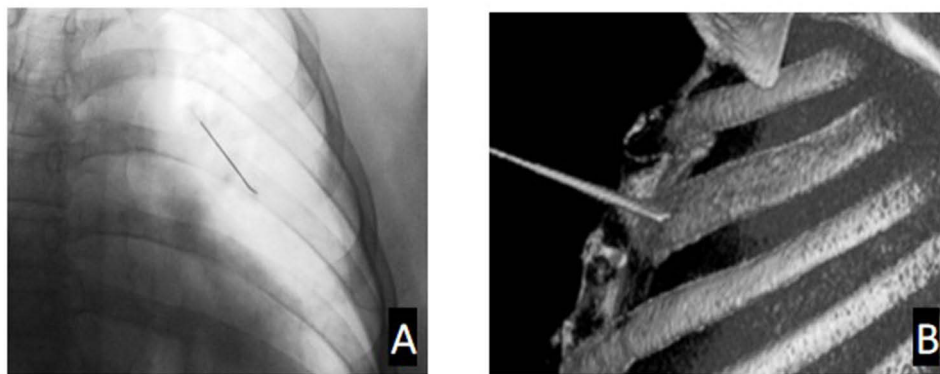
Initial cannula positioning during intercostal nerve radiofrequency ablation. (A) X-ray of the cannula position. (B) 3D CT of the cannula position.
